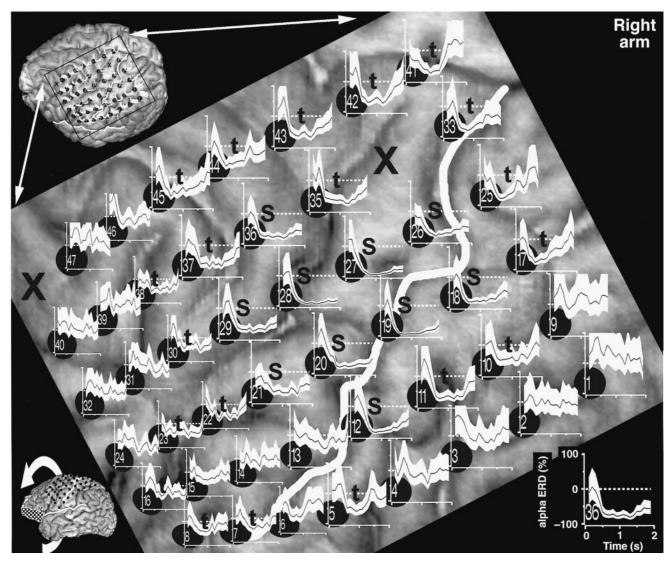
Plots of alpha ERD, for each subdural electrode over the left frontoparietal cortical regions, in Subject 1B during fist-clenching with the right (contralateral) arm during the simple visual—motor task. The horizontal axis shows post-stimulus time in seconds, and data points occur every 100 ms. Alpha ERD (geometric mean of the percentage change in post-stimulus alpha power from baseline) is plotted as a black line, and white areas above and below it represent 95% confidence intervals. 'S' denotes sustained alpha ERD, and 't' denotes transient alpha ERD (in at least three consecutive epochs). Plots are superimposed on the cortical surface anatomy of this subject, rendered from a 3D MRI (see brain in lower left corner), which is rotated laterally (see brain in upper left corner) to expose the entire array of electrodes. Solid white lines in insets demarcate the sylvian fissure and central sulcus, and the chequered area in the lower left brain image demarcates the maximal surface projection of an underlying region of frontal encephalomalacia. 'X' denotes an electrode site in which the ECoG could not be recorded reliably.
